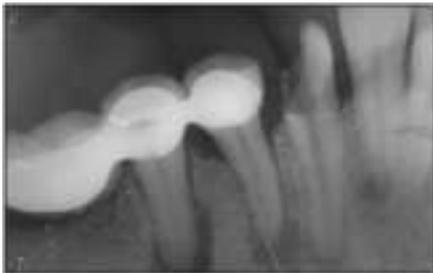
Confirmatory Radiograph Showing Origin of Sinus Present From Root Of Right Mandibular First Premolar
